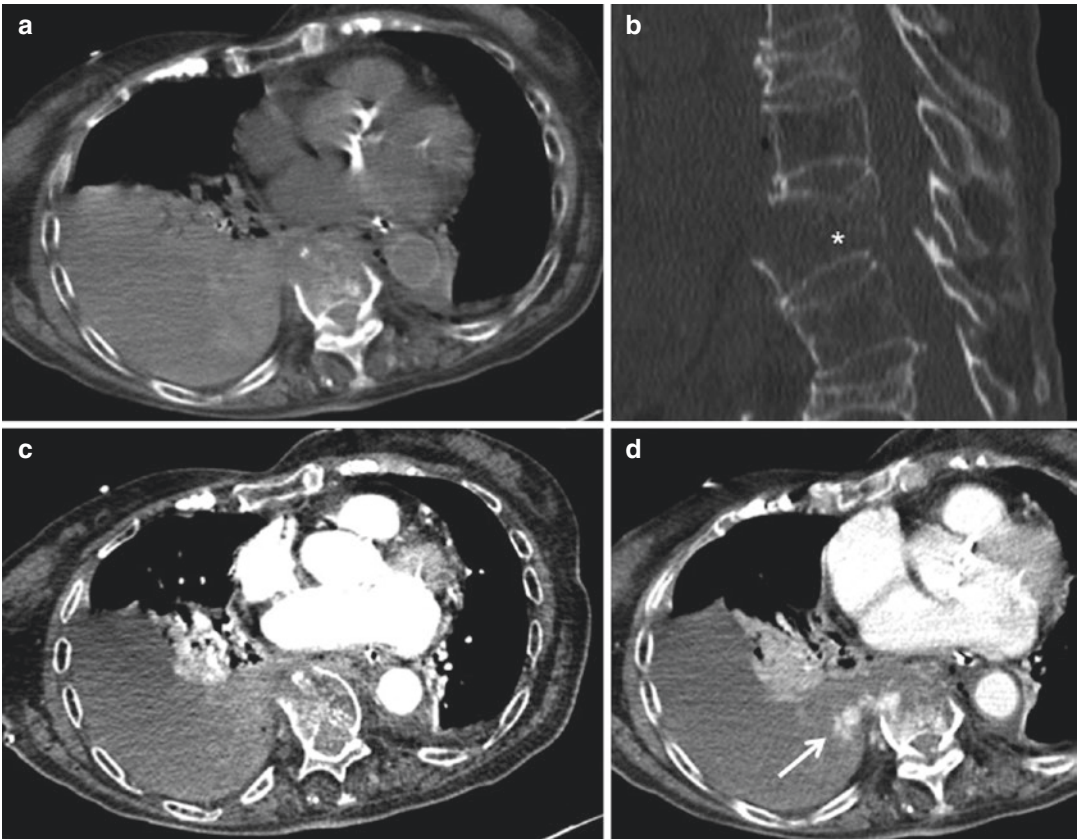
Right hemothorax with active venous bleeding: axial CT-scan at baseline (a) shows an inhomogeneous fluid collection with iso- and slightly hyperdense coexisting areas. No extravasation of contrast media can
